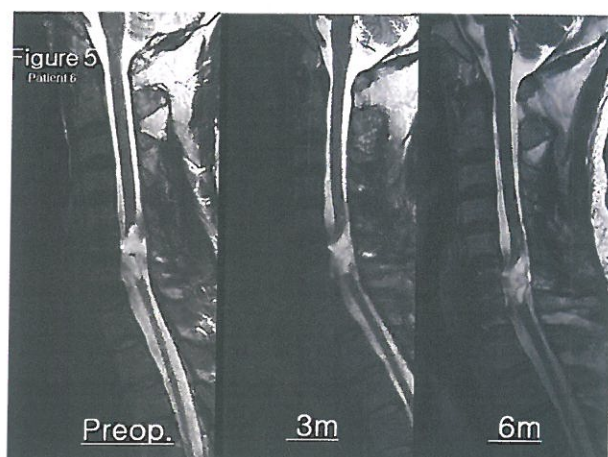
In Patient 6, high signal spot in proximal portion to contusion site of spinal cord was appeared and enlarged in T2 weighted image of the follow-up MRI.
